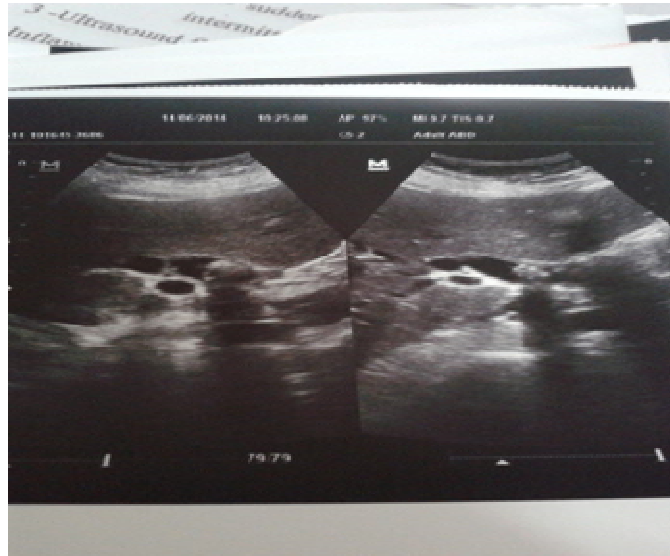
Ultrasound image of 32 years female showing common bile duct stone.
